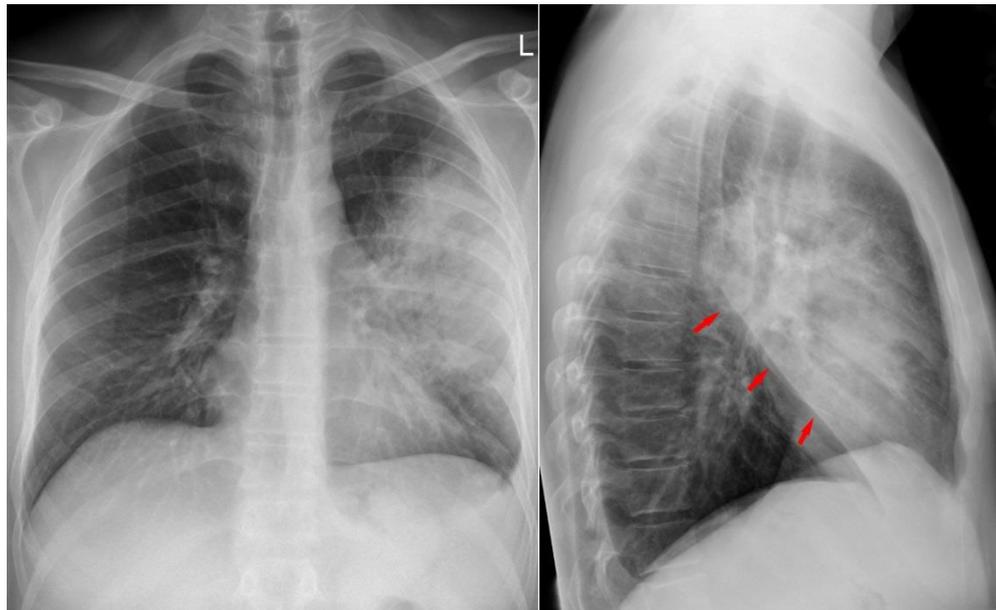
X-ray of a pneumonia diseased lung (cf. p. 49 for source of figure)
